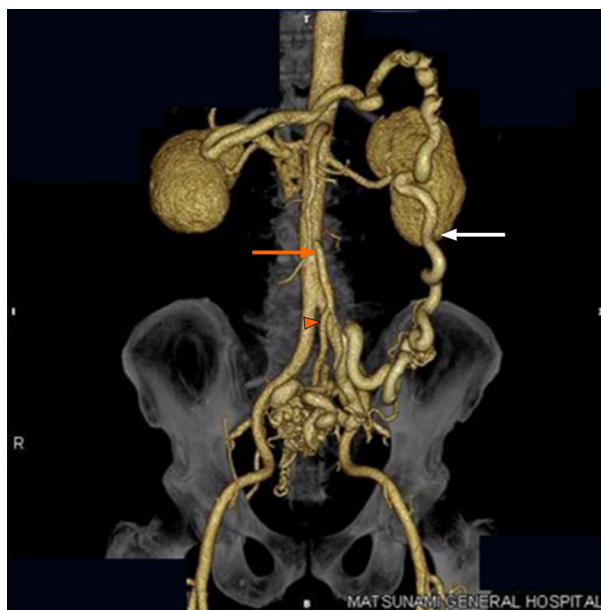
Image from computed tomography angiography. Computed tomography angiography showed the same findings as contrast-enhanced abdominal computed tomography. The image showed the nidus of small corkscrew and dilated vessels arising from the superior rectal artery (orange arrowhead), which is a branch of the inferior mesenteric artery (orange arrow). Dilated inferior mesenteric veins were observed (white arrow).
